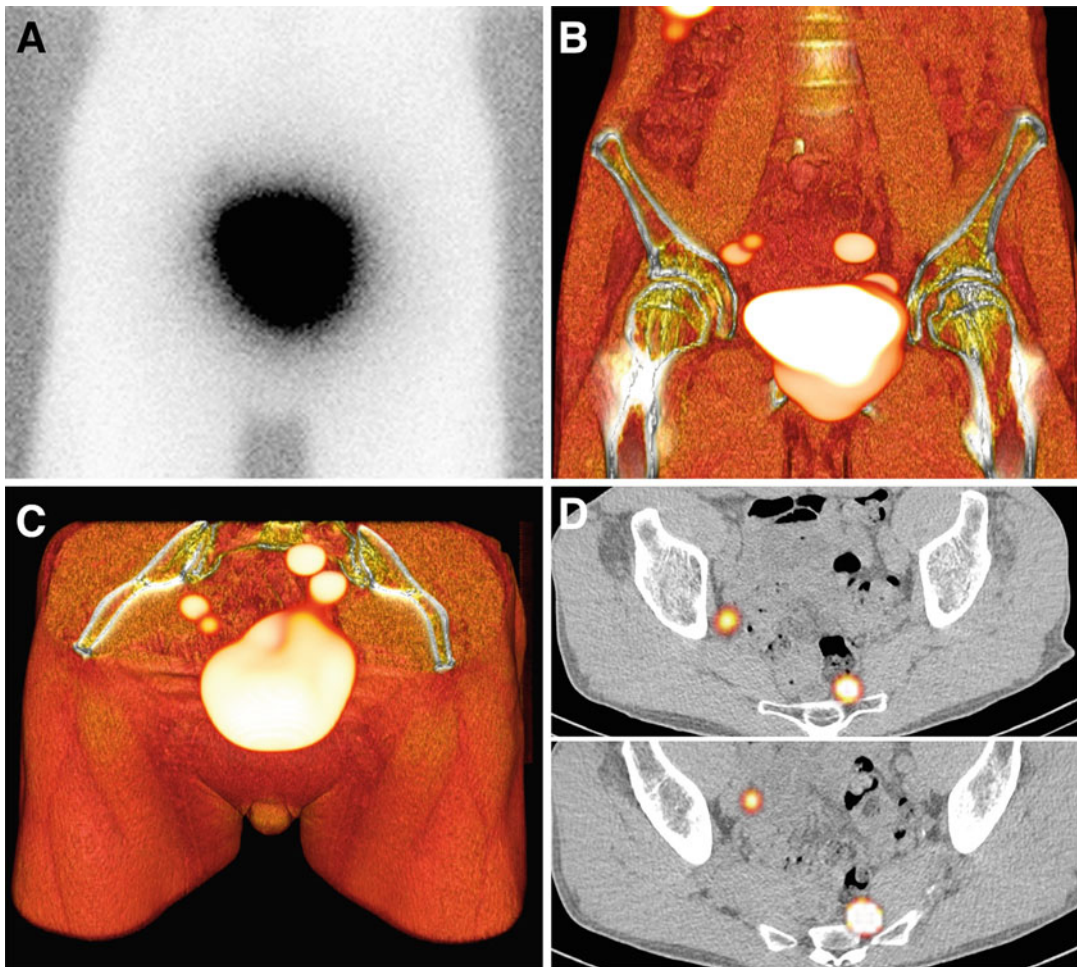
Planar lymphoscintigraphy (a) showing some drainage to the right iliac area in a patient who has received four injections of ^{99m}Tc -nanocolloid into the prostate. By contrast on volume rendering (b), bilateral drainage is
